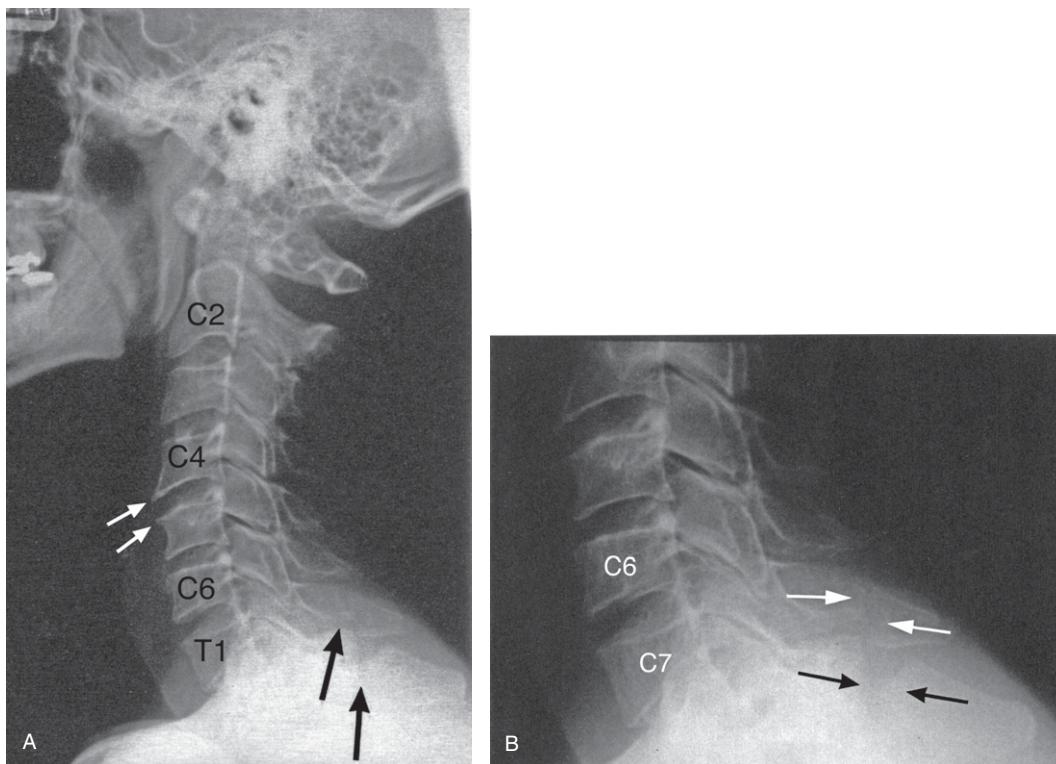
(A) Lateral cervical spine plain X-ray image. Note (i) degenerative changes in the cervical spine limited to the anterior margins of the C4 and C5 vertebral bodies at the C4–5 disc body junction (white arrows), and (ii) the C7 and T1 spinous process fractures (black arrows) with significant separation between the fractured fragments and the remaining spinous processes. (B) Enlargement of the C7 and T1 spinous process fractures (arrows) seen in [Figure 76.2A](#).
